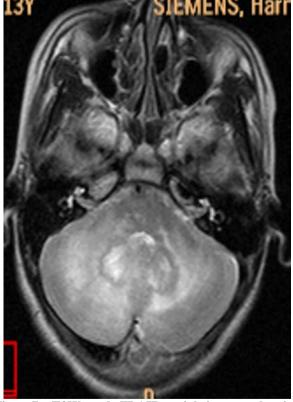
T2W and FLAIR axial images showing gliotic changes involving cerebellar hemispheres, vermis with significant atrophy.
